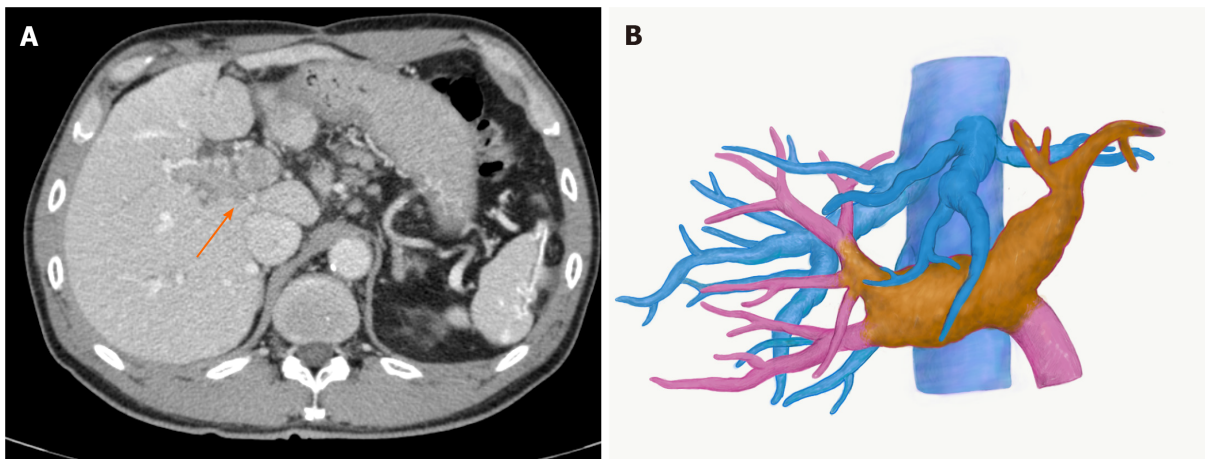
Images of hepatocellular carcinoma with portal vein tumour thrombus before lenvatinib treatment. A: Computed tomography image. An arrow indicates portal vein tumour thrombus; B: Three-dimensional image. The yellow mass demonstrates a viable portal vein tumour thrombus, extending to the contralateral third portal branch.
